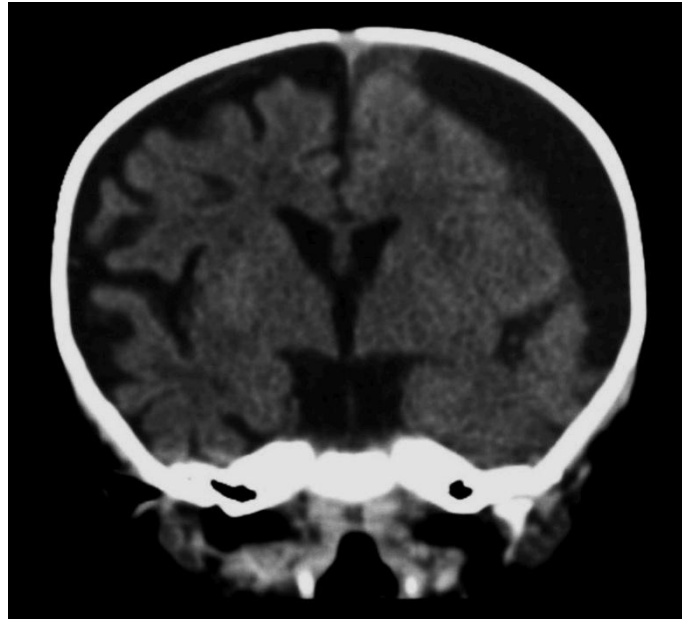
Coronal CT brain showing bilateral subdural hygroma more on left side
